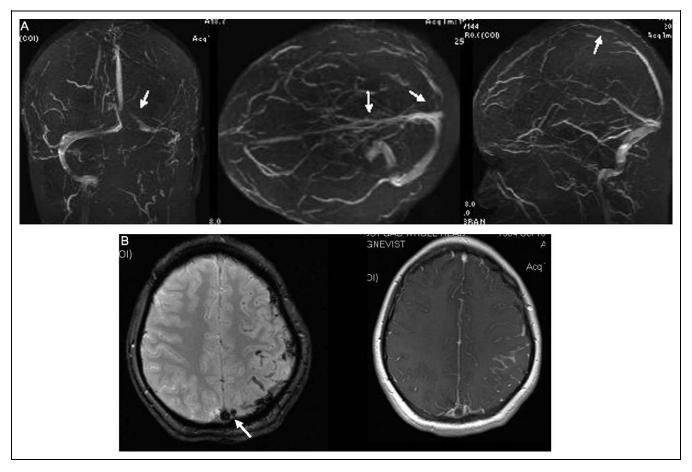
A, Left transverse sinus venous thrombosis with involvement of the jugular and sagittal vein in a woman 4 weeks postdelivery with an uncomplicated pregnancy. B, The same patient with cortical venous congestion and high signal in the superior sagittal sinus (Delta sign), apparent on magnetic resonance imaging (MRI) Gradient Imaging.
